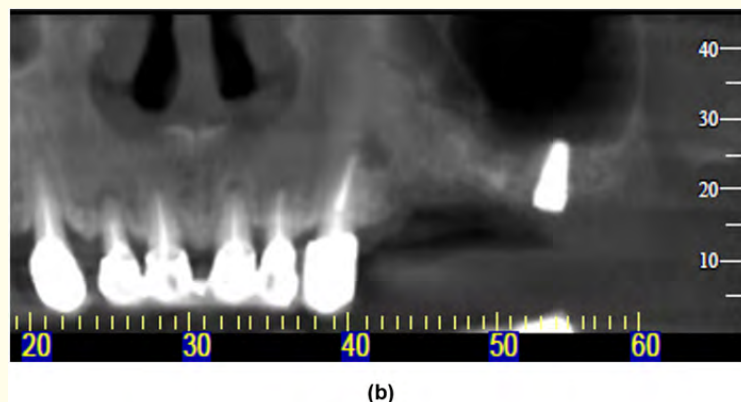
(a) The screw became fused to the implant because it was mistakenly soaked in povidone-iodine (Betadine) before placement, causing corrosive reaction. (b) Detail of the Post-op CBCT following implants placement in the upper left maxilla. (c) Detail of the Post-op CBCT region 53-54 following implants placement in the upper left maxilla showing complete osseointegration and bone height of approximately 9 mm. A vertical bone regeneration was observed.
